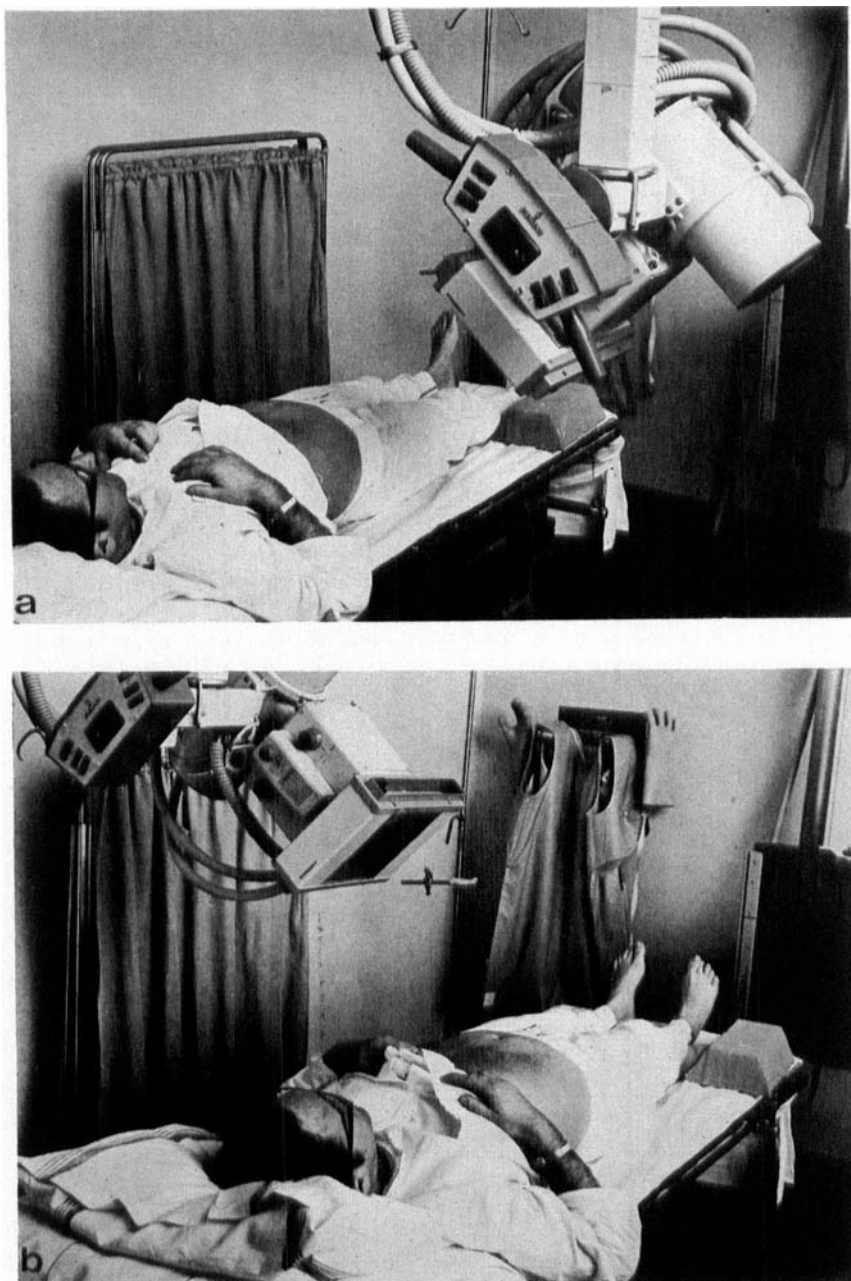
Instead of positioning the patient obliquely, the X-ray tube is positioned obliquely on both sides of the injured hip. In this manner, unnecessary handling of the injured patient is avoided (a and b).*
